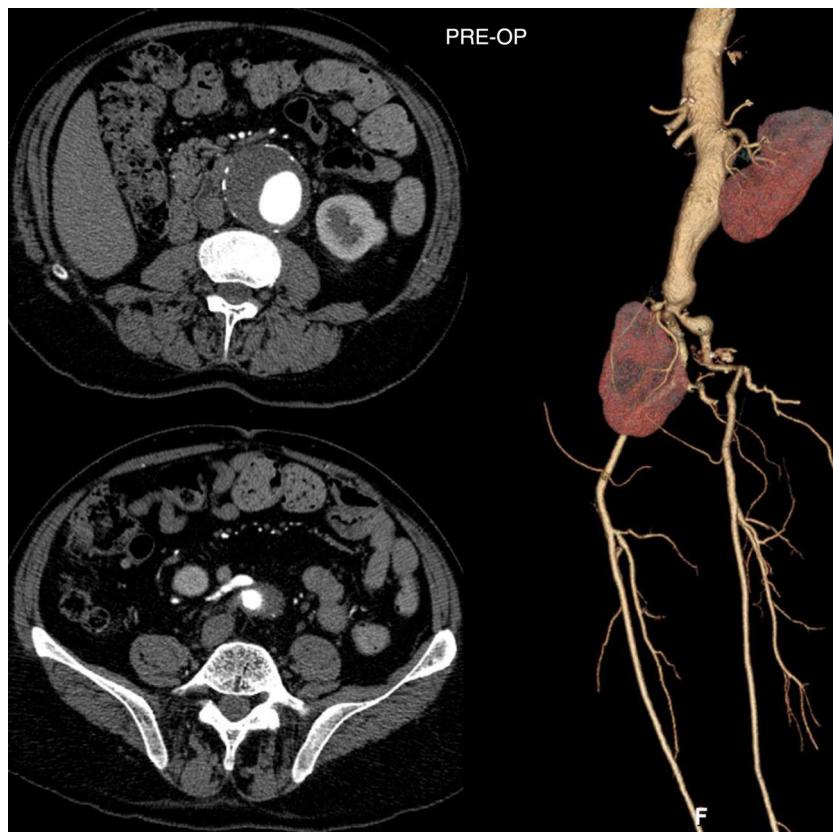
Pre-operative CT scan: ectopic right pelvic kidney vascularized by a single artery originated from the anterior wall of the abdominal aortic aneurysm.
